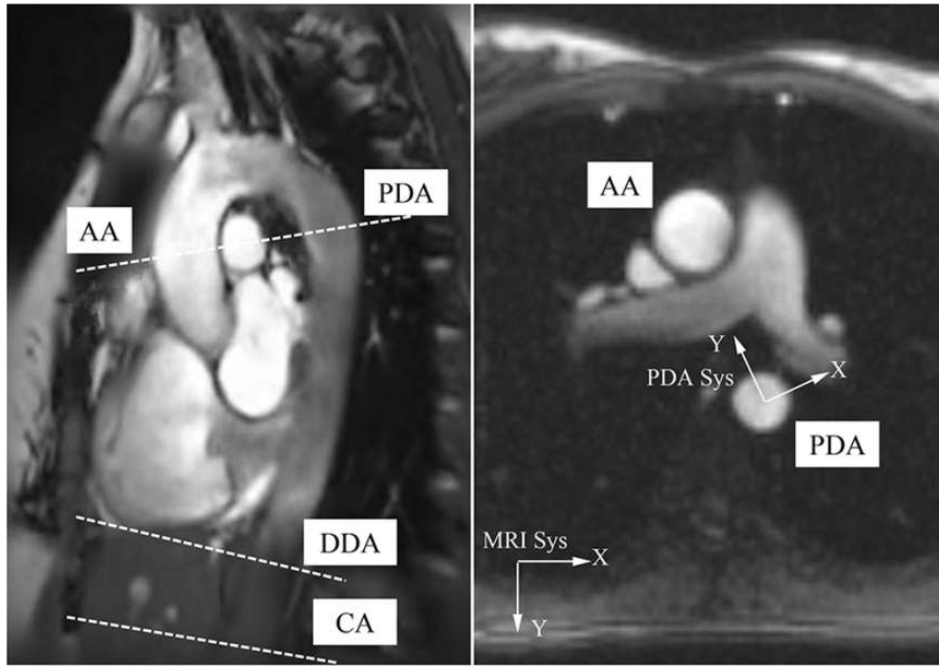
Oblique sagittal MRI image showing the locations of different aortic sections, the corresponding slice at AA for measuring its in-plane motion, the MRI reference system (MRI Sys) and the PDA system (PDA Sys)
